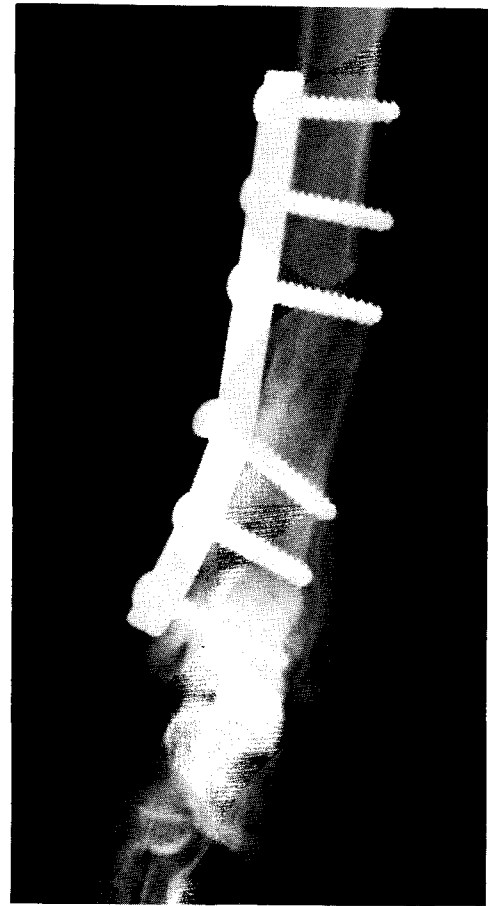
Postoperative radiograph at four weeks. The screws and plate are solid and there is good function of the leg.
